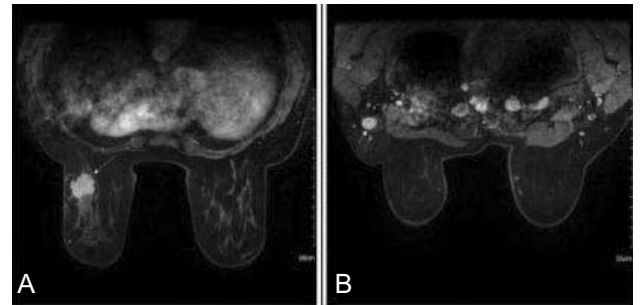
Early phase dynamic MRI images. A) A left breast lesion showing intense, heterogenous enhancement with linear enhancing projections into the breast parenchyme B) the largest axillary LAP
